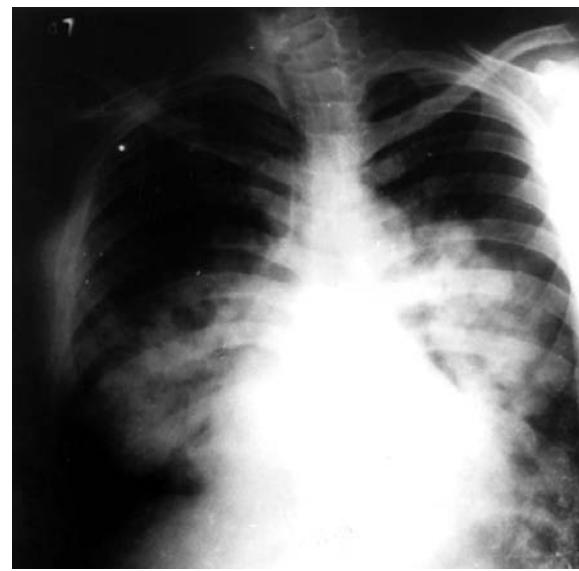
Heart failure. Chest X-ray (PA view) shows enlarged cardiac shadow with nonhomogenous opacification of the lungs from hila to periphery (pulmonary oedema)
